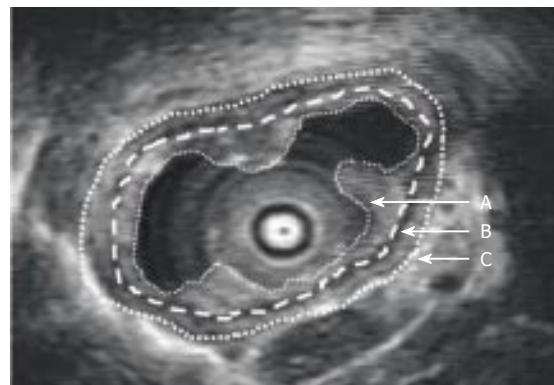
Transversal ultrasonographic image of the non-distended esophagus. The stippled lines indicate manual tracings of the mucosal inner surface (A) and the inner (B) and outer (C) lining of the combined muscle layers.
